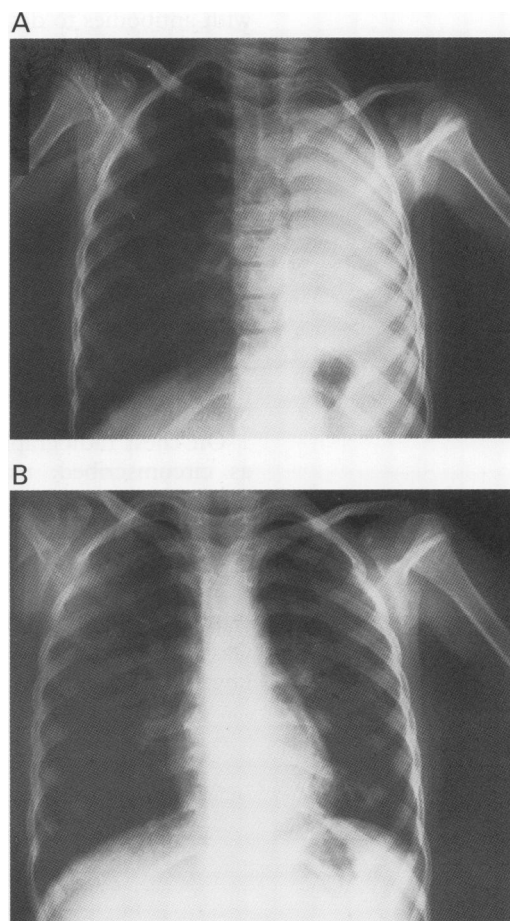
Chest radiographs taken (A) before bronchoscopy showing total atelectasis of the left lung and (B) after excision of the tumour.
